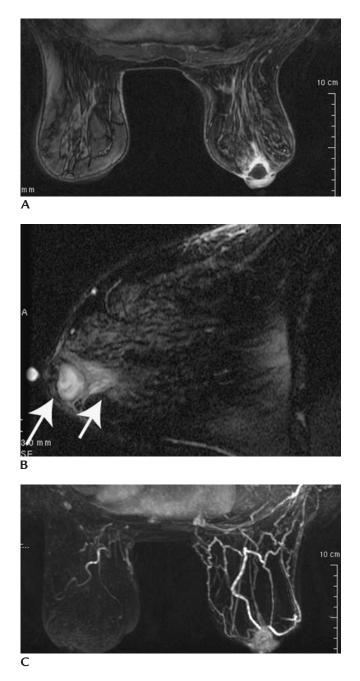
Subareolar abscess. (A) Magnetic resonance imaging. Delayed post contrast T1 weighted fast spin gradient image demonstrating right subareolar mass with rim enhancement and irregular/spiculated margins in patient with known subareolar abscess. (B) Sagittal T2 weighted image with fat suppression of the right breast demonstrating high signal intensity of abscess contents (*arrow*) as well as in surrounding tissue (*shorter arrow*) reflecting edematous change. (C) Maximum intensity projection demonstrating right subareolar mass with associated increased vascularity in the breast reflecting inflammatory change.
